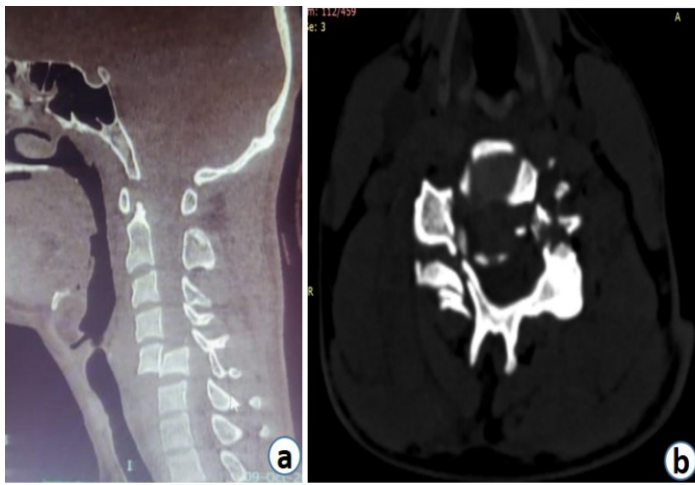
Figure 1: CT Mmid Ssagittal section (a) shows spondyloptosis of C5 over C6. The C5 vertebral body is lying just anterior to the C6 vertebral body. Axial CT (b) scan of the cervical spine shows right lateral mass complex is floating and left pedicle is broken for the C5 vertebral body. The remaining posterior arch is left behind. As a result, the overall spine canal size seems widened.
